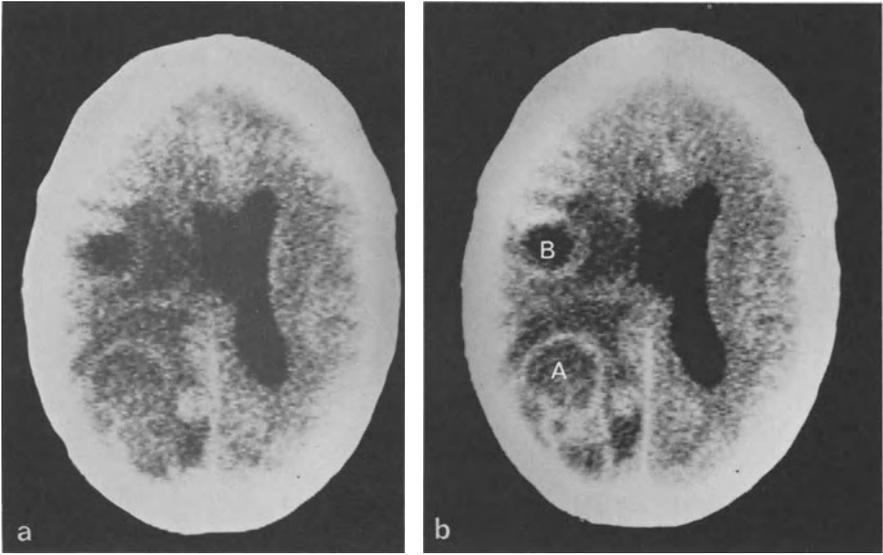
a CT with ring structures. b CT after contrast medium demonstrating abscess A and abscess B
